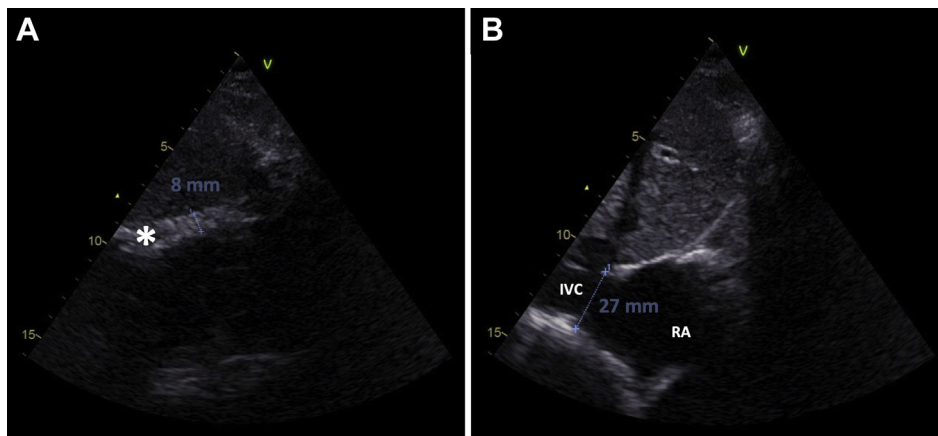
(A) Subcostal echocardiographic view showing calcified pericardium (white star) adjacent to the right ventricle free wall. (B) Dilation of the inferior vena cava (IVC) in its insertion in the right atrium (RA).
